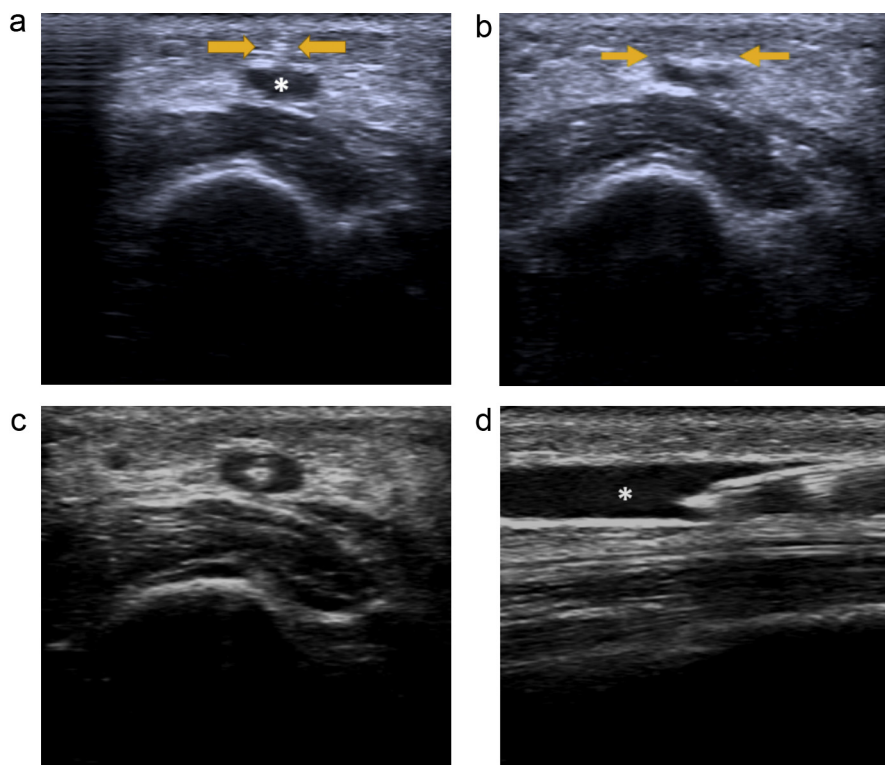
Sequential transverse ultrasound guided vessel access images from an upper extremity peripheral IV placement. (a) Advancing needle into the subcutaneous tissues superficial to the vessel (arrows), the probe has been moved proximally along the arm to visualize the tip of the needle (arrows) in relationship to the target vessel (*) during advancement; (b) further advancement of needle tip now "tenting" the target vessel (arrows), the ultrasound probe has again been advanced proximally to ensure visualization of the venipuncture; (c) the needle tip is visualized in the target vessel during further advancement to ensure adequate purchase, note the centered needle tip appears as a "bullseye"; longitudinal view (d) during the same access, note that the access needle length as well as the target vessel (*) is visualized in one plane.
